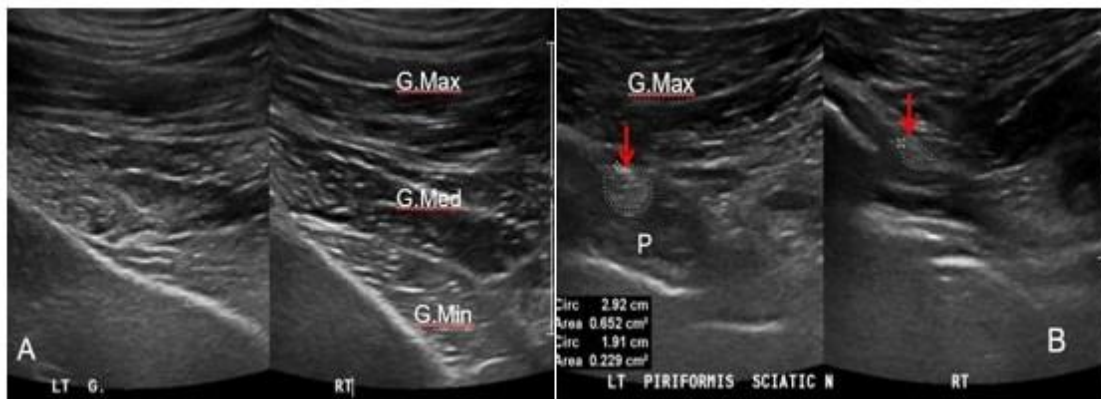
Ultrasound images of left spontaneous gluteal rhabdomyolysis. Transverse ultrasound image showed left gluteus medius and minimus muscles degeneration (A) and swelling of left sciatic nerve (arrow) compared to the right one (B). G. Max; Gluteus maximus, G. Med.; Gluteus medius, G. Min.; Gluteus minimus, P; Piriformis
